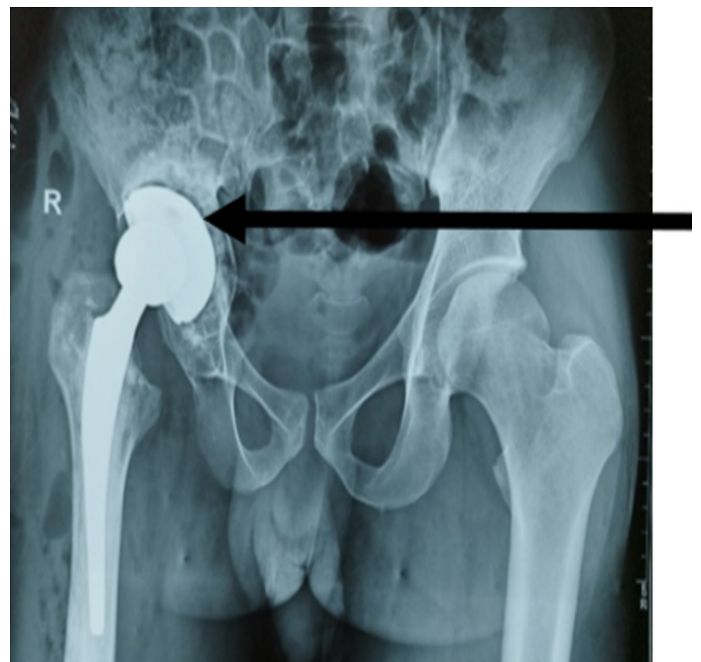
Radiograph of a patient showing a lucent line between the prosthetic acetabulum and the native acetabulum, indicating loosening of the cup.
